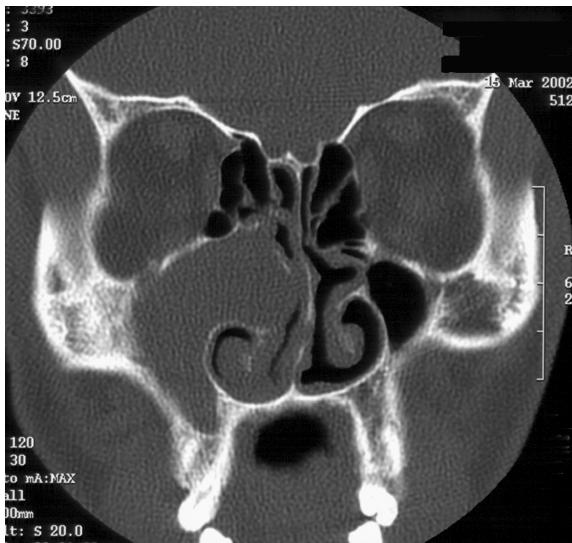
Coronal CT scan, bone windows, soft tissue mass obstructing the right osteomeatal unit and complete opacification of the right maxillary antrum. Bony erosion noted along the right maxillary medial wall.
